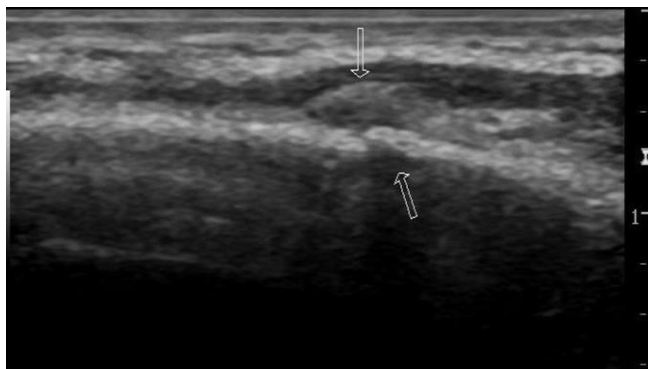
Ultrasound chest showing fracture ribs
